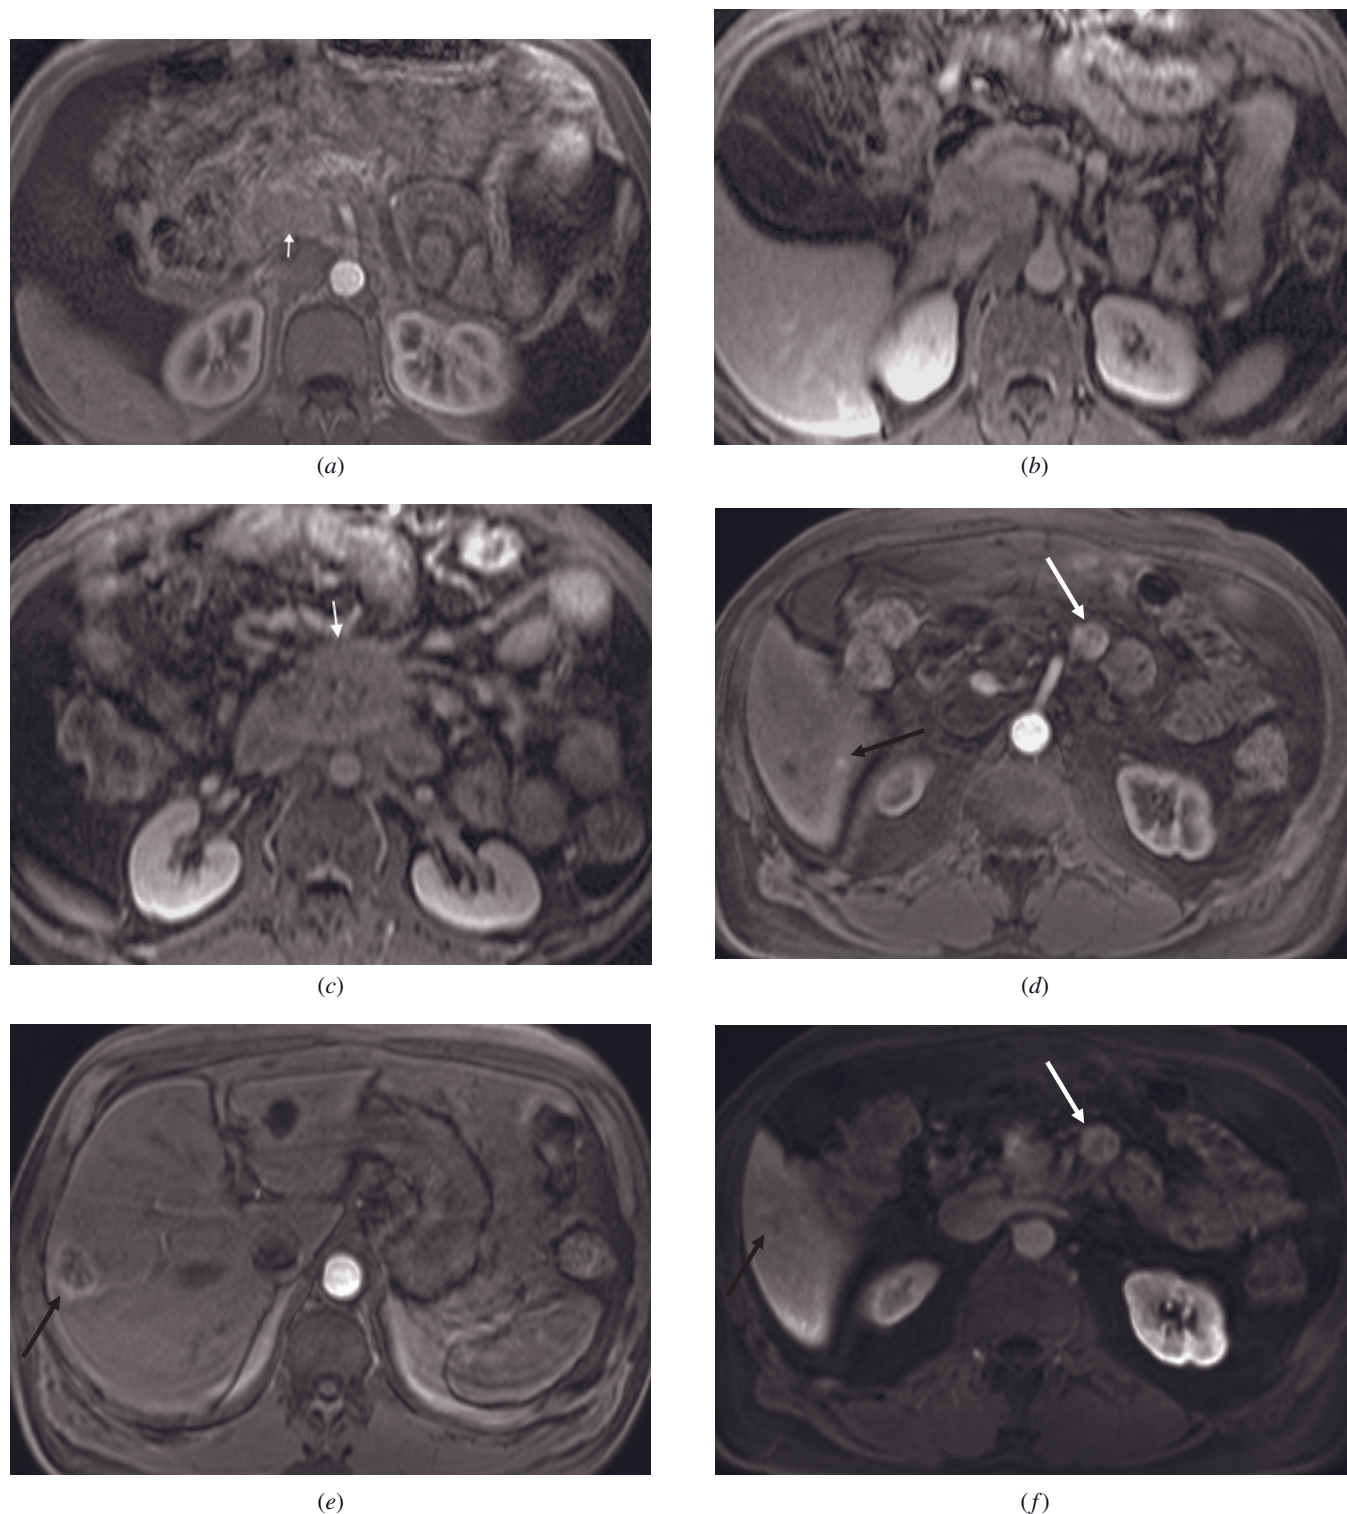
Pancreatic carcinoid tumor. Immediate postgadolinium fat-suppressed T1-weighted gradient-echo (*a*) and 90-s postgadolinium fat-suppressed T1-weighted 3D gradient-echo (*b*, *c*) images from one patient show a large mass arising from the head of the pancreas (arrow, *a*). The mass enhances in a diminished fashion on immediate postgadolinium image (*a*), and “a” pancreatic tumor and a large mesenteric mass (arrow, *c*) are shown on interstitial-phase images. The presence of an associated large mesenteric mass is typical for carcinoid tumors. Lack of pancreatic duct dilation and atrophy of the body of the pancreas in the setting of a large pancreatic head mass are typical of a neuroendocrine tumor and not consistent with pancreatic ductal cancer.
